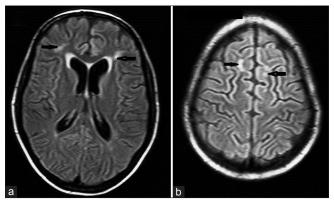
FLAIR magnetic resonance imaging brain revealing few periventricular (a, arrows) and centrum semiovale (b, arrows) white matter hyper intensities
